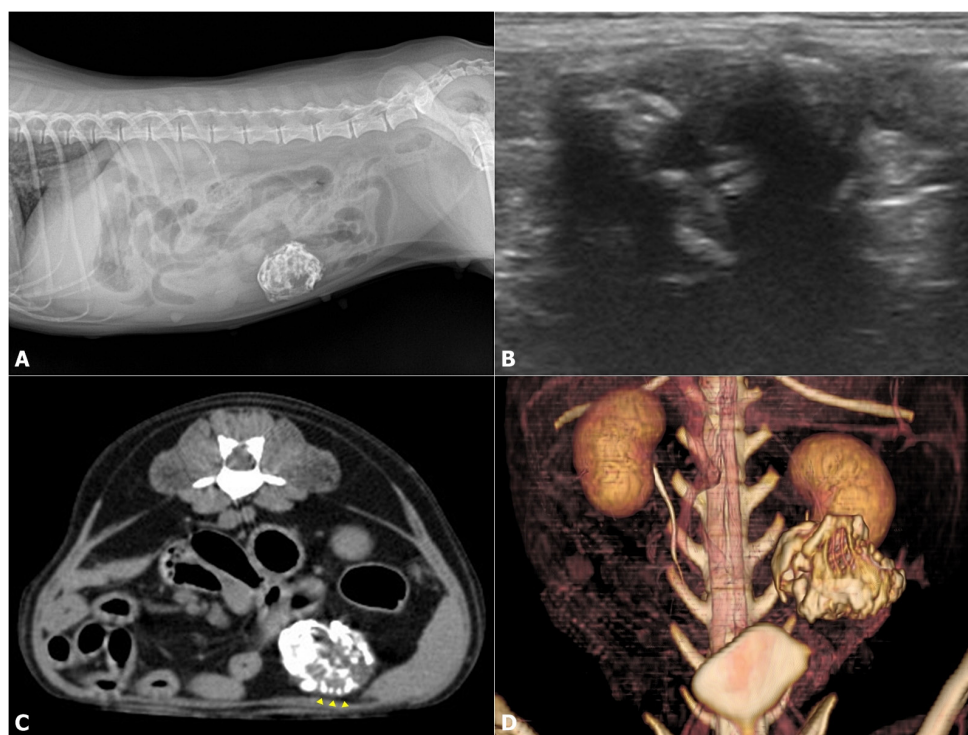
(A) Lateral abdominal radiography. A round-shaped mass with bony opacity was identified in the ventral mid-abdomen. (B) Ultrasonography of abdomen. Hyperechoic foci were revealed, with no vascular response in the mass. (C) CT scan of abdomen. There is no evidence of continuity with any other abdominal organs except possible adherence to the ventral aspect of the abdominal wall and segments of the intestines. Bony attenuated structures arranged in discontinuous and consistent patterns were observed in the mass (arrowheads). (D) 3D-reconstructed CT image
